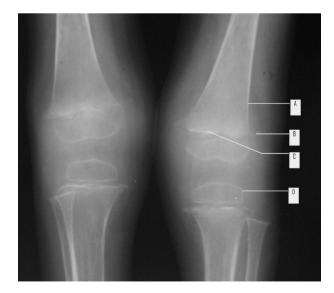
Radiographs of the both knee showing (A) pencil thin cortex, (B) pelkan spurs, (C) Fraenkel line, (D) ring epiphysis. The radiographs show a washed out appearance.
